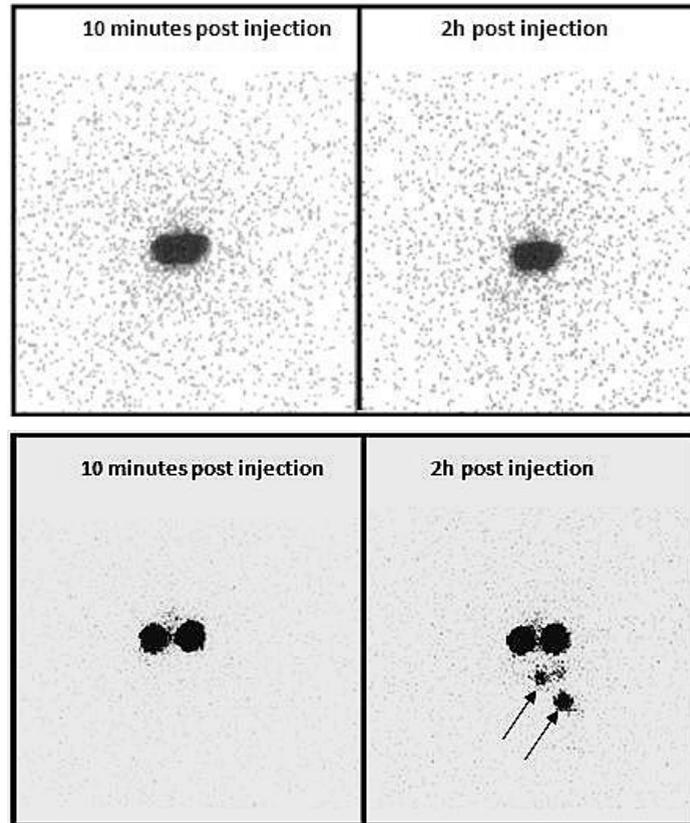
A) Initial lymphoscintigraphy after bilateral injection of tracer into the lips (Case 2). B) Follow-up bilateral lymphoscintigraphy after 1.5 years demonstrating visualization of local lymph nodes (arrows).
